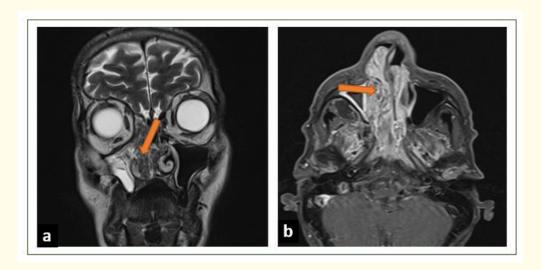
MRI nasosinusal; (a) coronal section in T2 showing hyposignal processus of the right nasal cavity with destruction of the middle concha. (b) axial section in T1 enhanced showing cerebriform enhancement typical of an inverted papilloma with maxillary obstructive sinusitis.
